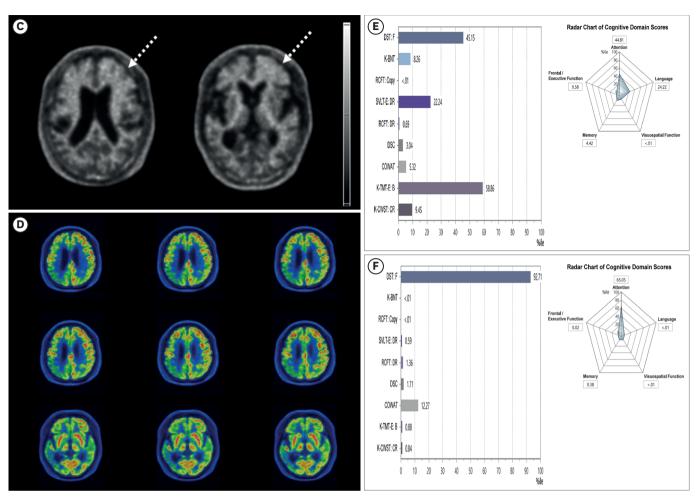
(Continued) (A, B) Brain MRI of the patient. Compared to the previous study (A), transaxial MRI after 3 years show atrophic changes in right frontal and temporal cortices around the sylvian fissure (red arrow, B). (C) Transaxial amyloid PET images show asymmetrical amyloid deposition patterns. A greater amyloid deposition is observed in the left frontal cortex (dashed arrows). (D) Transaxial ¹⁶F-fluorodeoxyglucose PET images exhibit a decrease in metabolism in the right fronto-parieto-temporal occipital lobe, right caudate nucleus, right basal ganglia, left parietal, and bilateral posterior cingulate gyrus (more severe in the right side). (E) Results of SNSB performed at the patient's initial visit. (F) Results of SNSB performed at 1-year follow-up.
